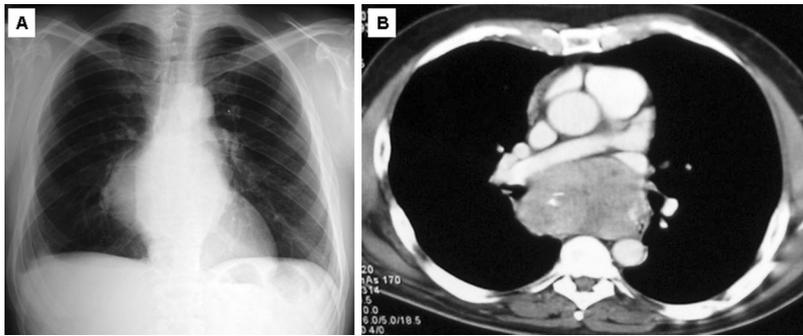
A, x-ray chest showing large central mediastinal mass. B, Chest CT scan showing the size of the mass and its anatomic relations.
